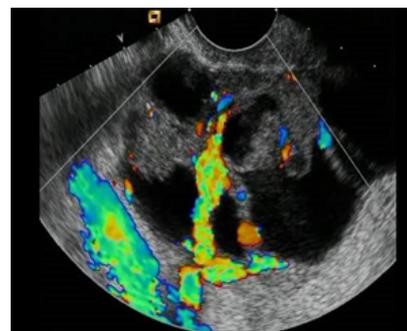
Ovarian cancer diagnosis using ultrasound which detect malignant adnexal masses better than MRI. Adapted from AMP Medical daily by Stephanie Castillo on Tuesday, January 19, 2016-10:50 [9].
